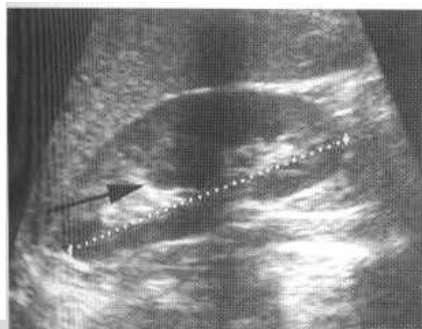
(A) Longitudinal renal ultrasound scan showing a prominent column of Bertin (arrow). (B) Transverse scan showing the same feature (arrow).
